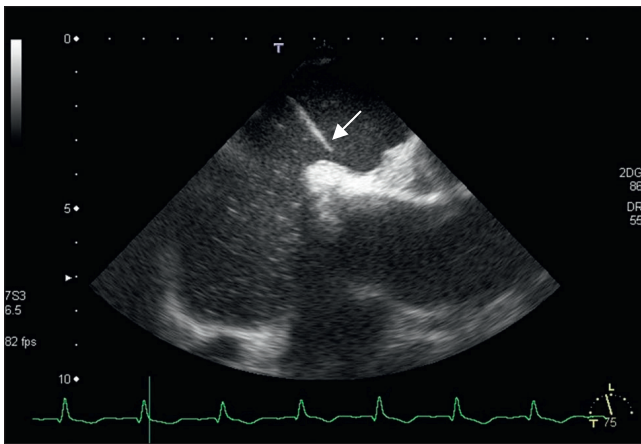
Transesophageal echocardiography. Patent foramen ovale with right-to-left shunting (arrow)
